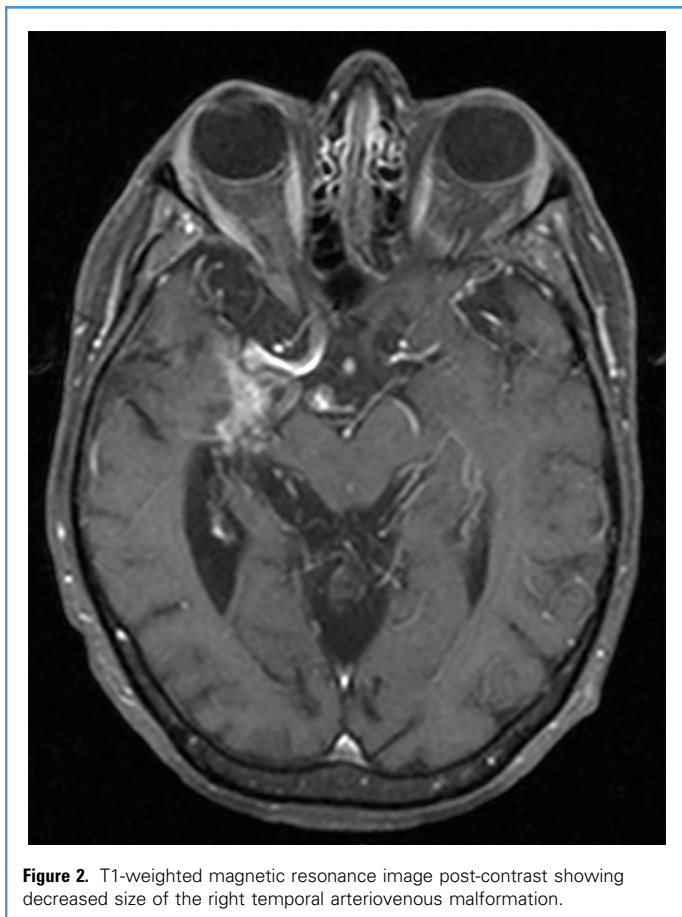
T1-weighted magnetic resonance image post-contrast showing decreased size of the right temporal arteriovenous malformation.
